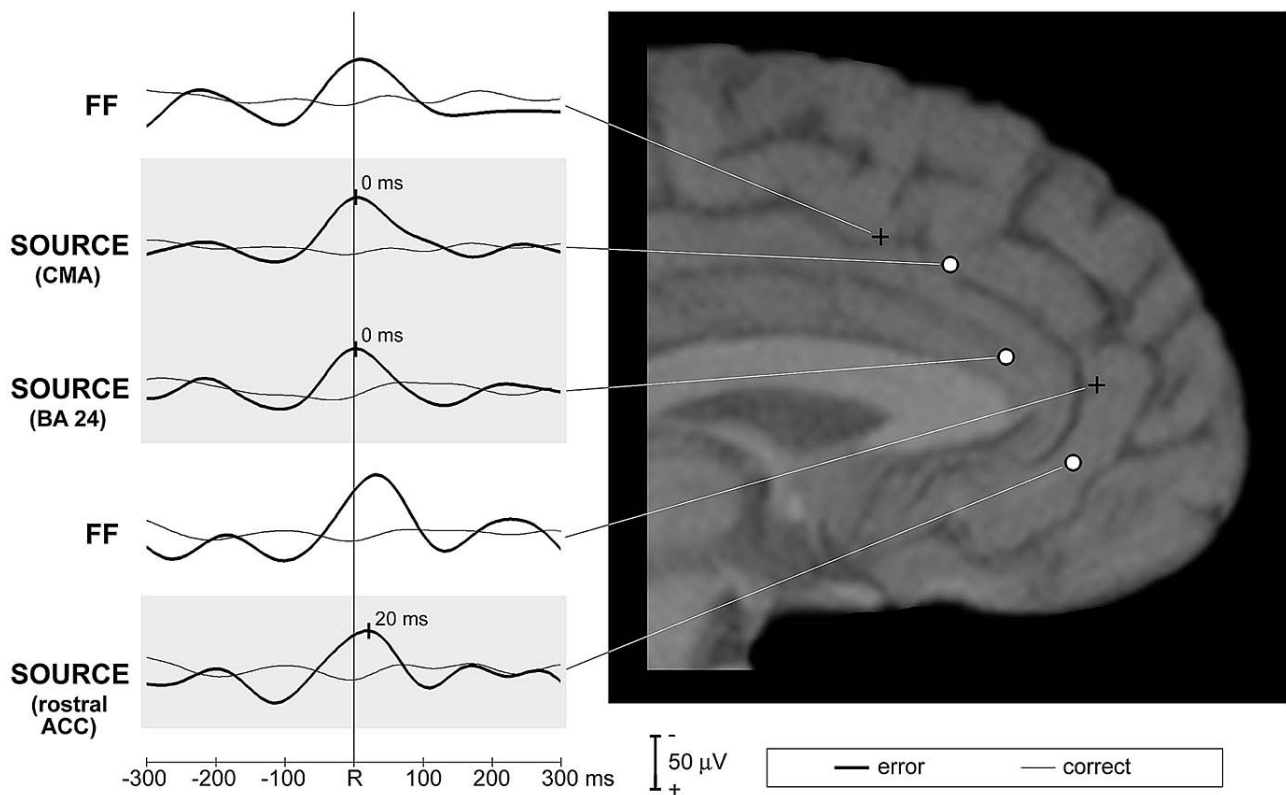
A time delay between intracerebral Ne/ERNs generated within different ACC sub-areas (response-triggered averages from cingulate motor area – CMA: –7, 20, 30 – Ne/ERN latency = 0 ms; BA 24: –2, 31, 14 – Ne/ERN latency = 0 ms; rostral ACC: –5, 34, –5 – Ne/ERN latency = +20 ms). The position of the recording sites (right) is precisely indicated on the subject’s MRI scan (verified using postplacement MRI). Subject no. 1. FF – far field (spreading of the Ne/ERN activity).
